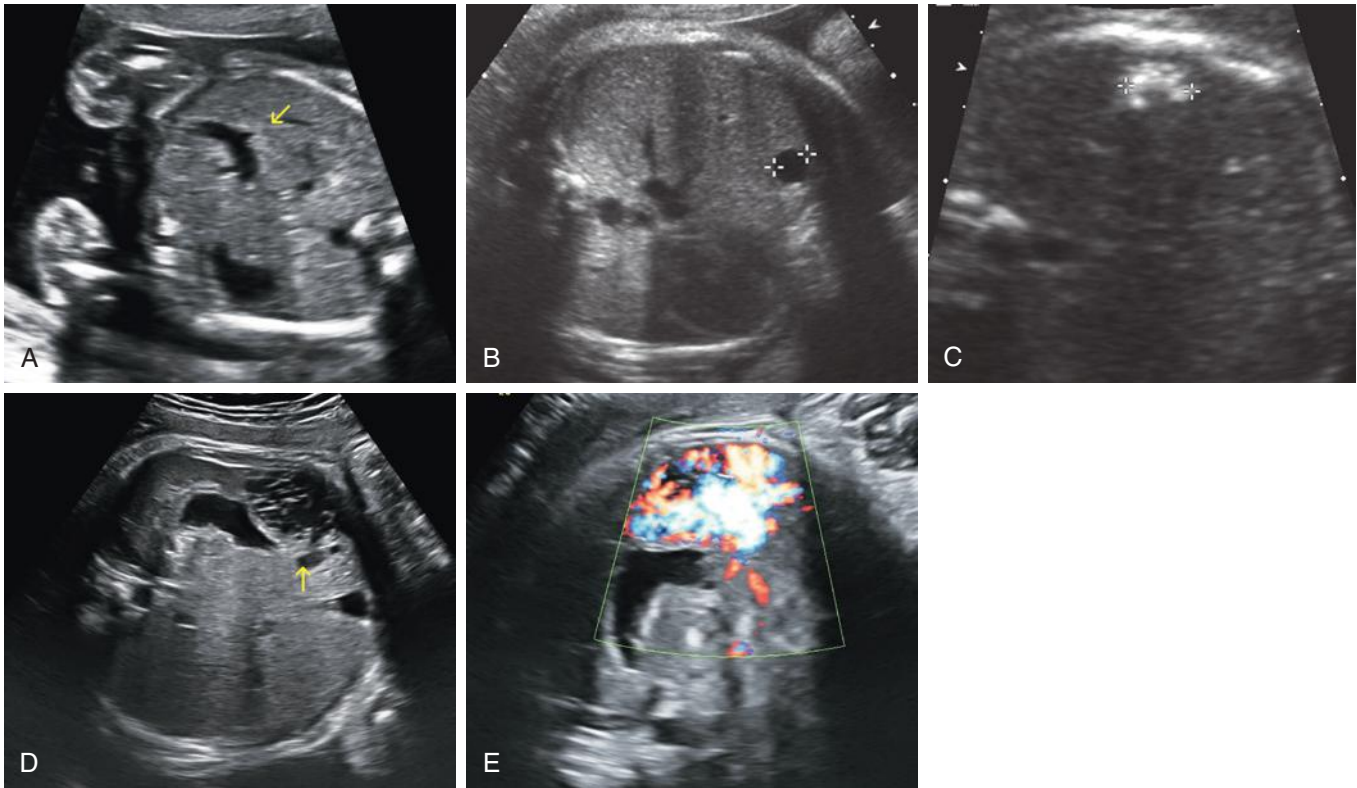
Liver malformations. A, Persistent right umbilical vein (*arrow*), curving toward the left-sided stomach (compare to Fig. 14-2A). This fetus also had a horseshoe kidney, which was confirmed after birth. B, Small round anechoic hepatic cyst (*cursors*) seen on an oblique transaxial sonographic image of the upper abdomen. C, Hepatic calcification (*cursors*). Note the intraparenchymal dense echogenic foci at the periphery of the liver with slight posterior acoustic shadowing. This observation would prompt testing for possible infection, such as cytomegalovirus. D, Hepatic arteriovenous malformation (*arrow*). Heterogeneous hypoechoic mass within the left hepatic lobe, adjacent to the fluid-filled stomach. E, The same fetus as in D, with color Doppler sonography demonstrating marked vascularity. This lesion gradually involuted over the first 6 months of life.
